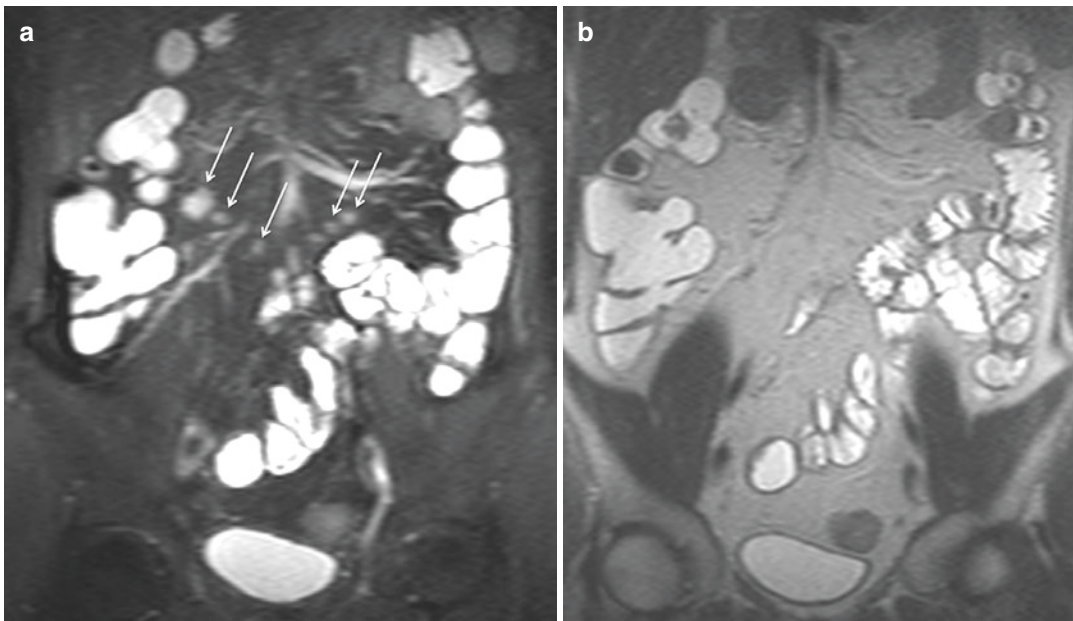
Reactive adenopathy. Coronal T2-weighted fat-saturated image (a) well depicts multiple mesenteric lymphadenopathies (arrows), less evident on coronal
